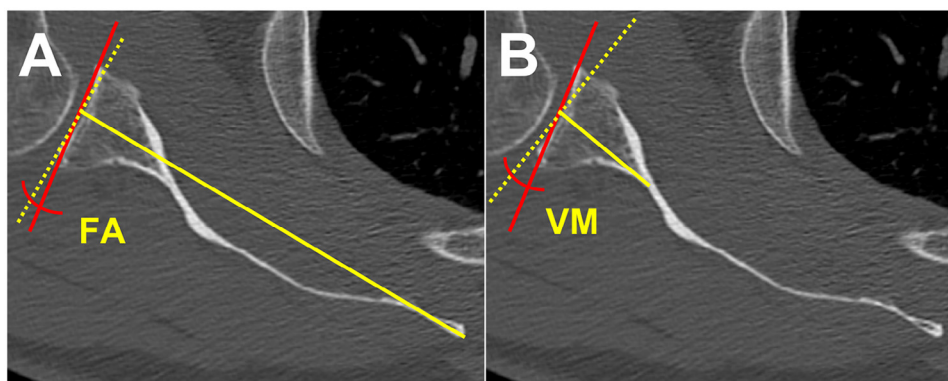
Axial computed tomography slice showing glenoid version measurement according to the Friedman angle (FA) (A), taking the medial border of the scapula as the reference point, and the vault method (VM) (B), taking the tip of the glenoid vault as the reference point.
